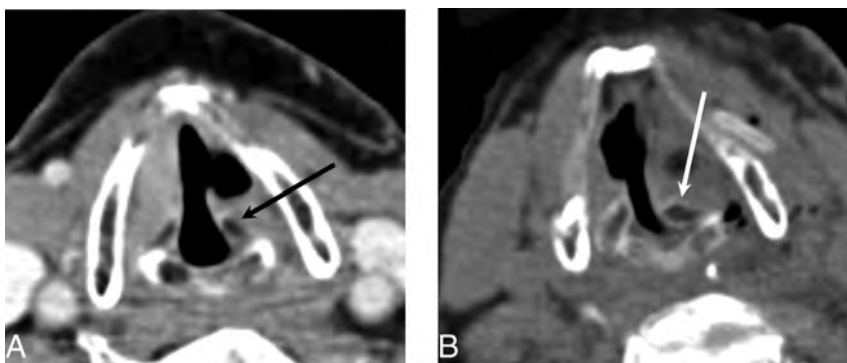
Arytenoid adduction. Preoperative axial CT image (A) and postoperative axial CT image (B) demonstrate the medially rotated (adducted) left arytenoid cartilage (white arrow) compared with the preoperative position (black arrow). Note that adduction turns the arytenoid in toward the vocal cord to ensure that no air leaks through the posterior glottic gap. This result helps patients achieve a more robust voice quality after the operation.
